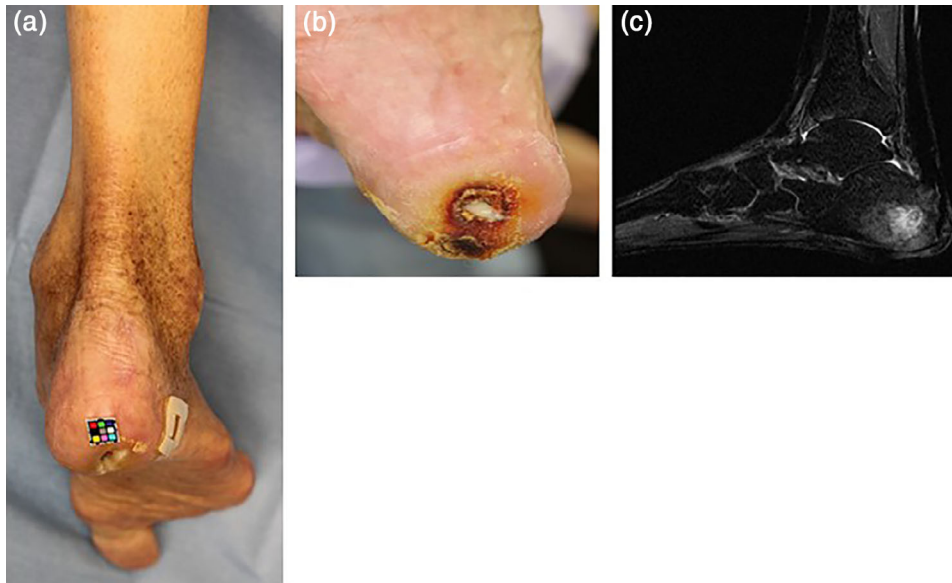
A case of a calcaneal callosity developing into possible calcaneal bone osteomyelitis. (a) Skin is generally in good condition from the distal one-third of the lower extremities to the foot region. (b) Pus from the ulcer on the heel region. (c) Magnetic resonance imaging: sagittal section of the foot. Fat-suppressed T2-weighted image shows high signal intensity in the calcaneal bone marrow, which reflects osteomyelitis.
